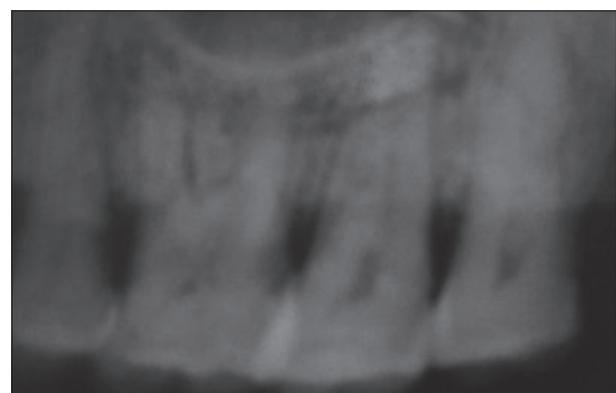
Pre-operative intraoral periapicalradiograph showing horizontal bone loss
